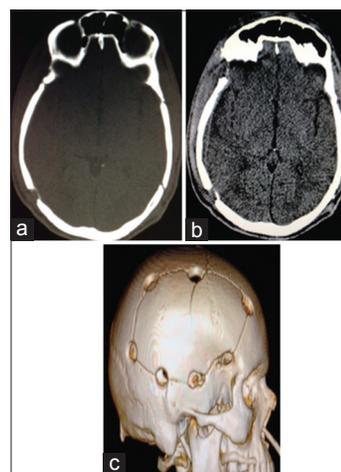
Post operative computer tomography (CT). (a) Skull CT with bone window demonstrating bilateral fractures and on the left posterior side one of the trepanation points. (b) Brain CT indicating resolution of the bilateral hematomas and subsequently resolution of the midline shift (c) 3D skull reconstruction presenting the trepanation points
